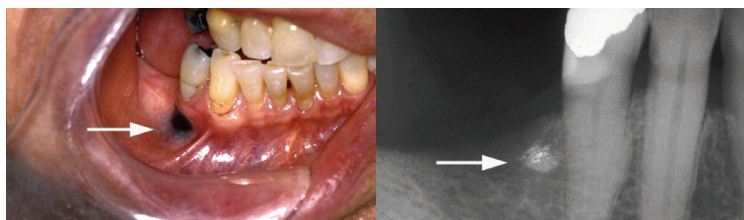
Pigmented lesion suspicious of an amalgam tattoo and radiograph of the same patient showing radiopacities thereby confirming an amalgam tattoo.
